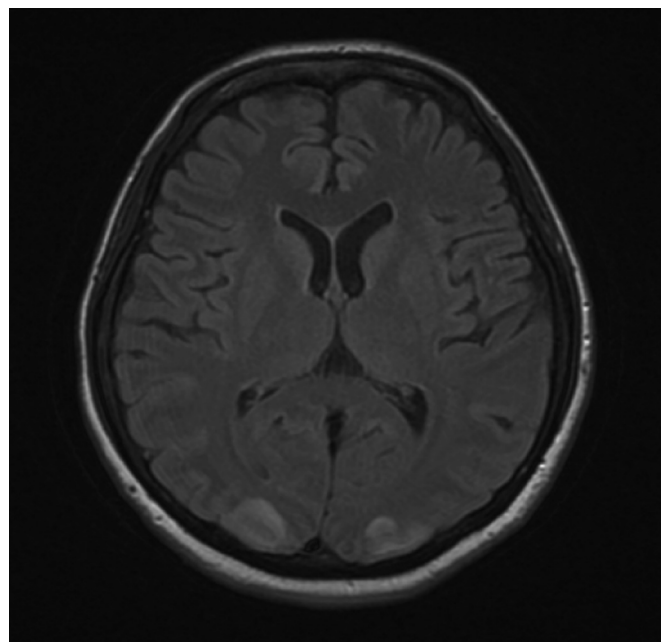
Brain magnetic resonance imaging. T2-weighted imaging shows hyperintensity of the sulci of bilateral occipital lobes.
